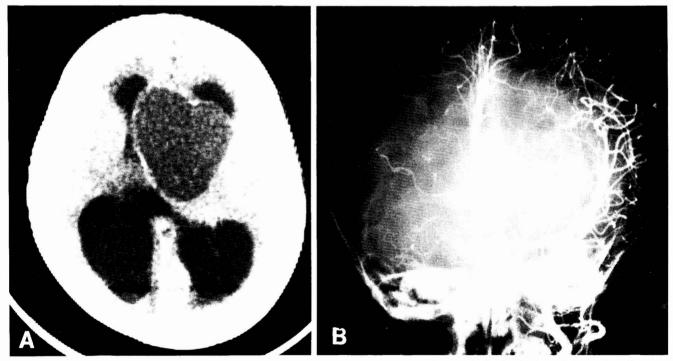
Case of craniopharyngioma in the presence of a prefixed chiasm. A: Enhanced CT scan indicating hydrocephalus and cystic tumor with enhancing walls. Tumor pushed the floor of the 3rd ventricle upward from its retrochiasmatic position. B: Left carotid angiogram of the same patient. The A-1 arteries lie above a relatively immobile prefixed chiasm and so are not elevated by this large tumor.
